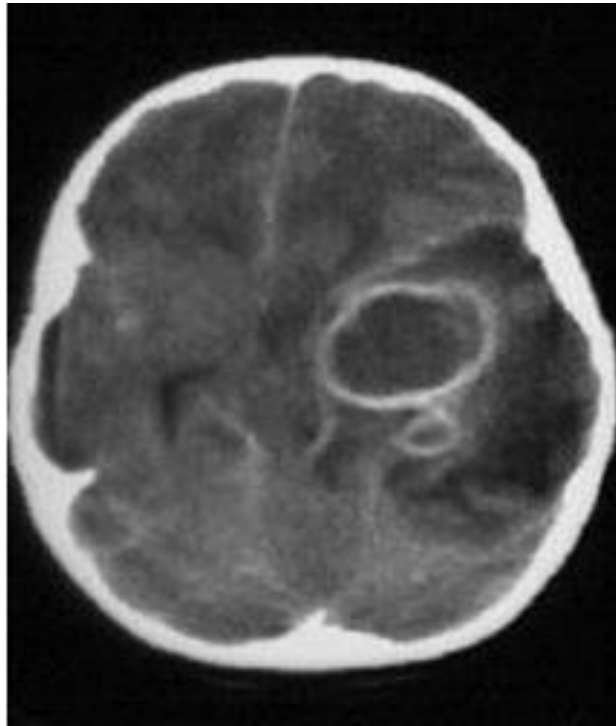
Brain cyst with contrast (Interpretation of Emergency Head CT Erskine J.et.al 2008).
